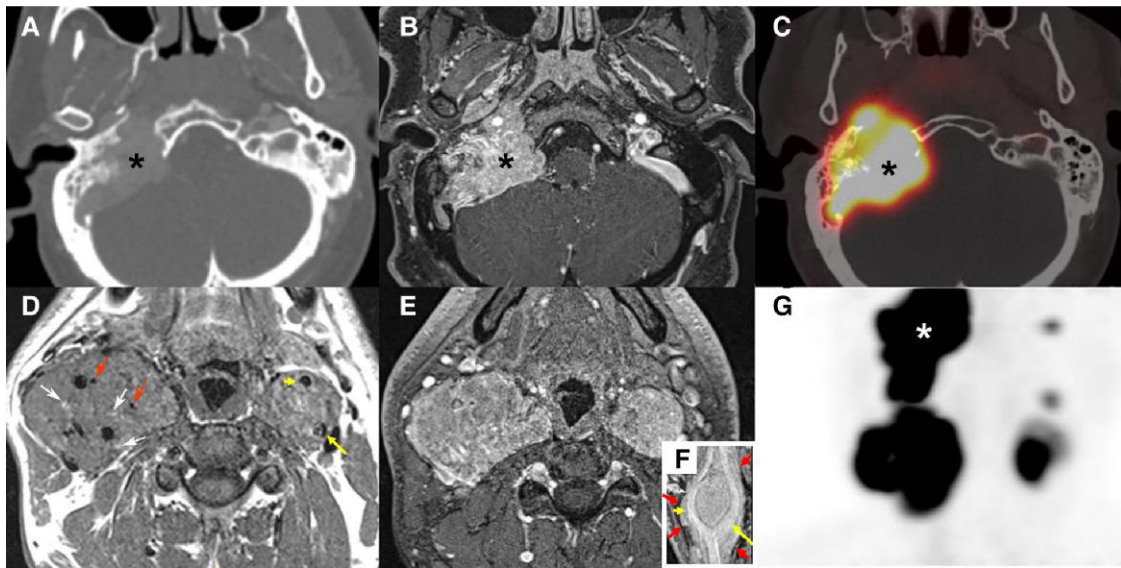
CT, MRI, and ^{68}Ga -DOTATOC PET/CT of multifocal *SDHD*-related HNPGLs. Temporal bone CT (A), MRI (B, D, E), ^{68}Ga -DOTATOC PET/CT (C, F). Right jugular PGL (A-C; asterisk, stage Fisch Di) with bilateral shamblin III carotid PGLs (D, E). Note the salt and pepper appearance on T1 (D, salt/white arrows = hemorrhage foci; pepper/red arrows = flow voids) and lyre sign (F, long yellow arrow: internal carotid artery, short yellow arrow: external carotid artery, short red arrows showing the limits of the PGL). On ^{68}Ga -DOTATOC PET/CT: multiple SSTR-expressing PGL. Note the 2 left small foci corresponding to a small vagus nerve and a jugular PGL, respectively.
